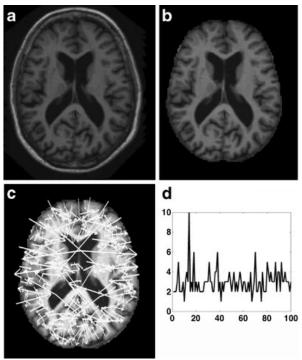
Example MRI scan of a brain, with c showing the orientation of extracted key-points and d showing one of the key-point histograms from one of those points (Daliri, M., 2012)
